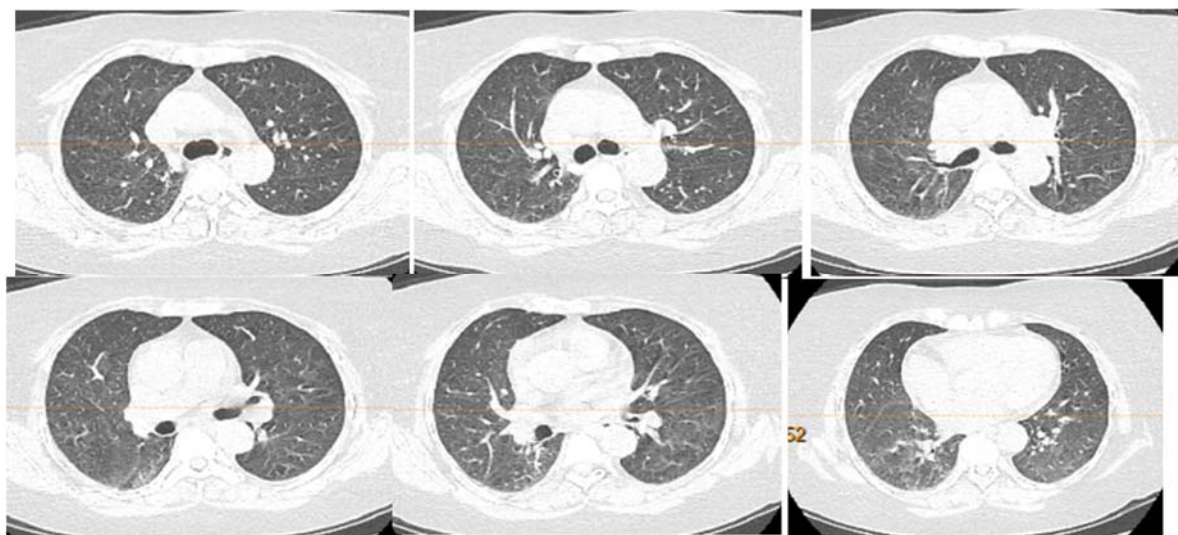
Axial lung windows of the high-resolution chest CT scan revealing marked resolutions of the alveolar infiltrate and ground-glass opacity after 6 weeks of PTU withdrawal, steroid, and monthly cyclophosphamide treatment, with the restoration of the lung parenchyma.
